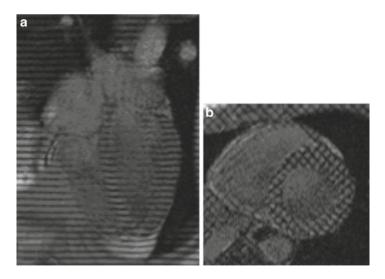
Tagged long-axis (a) and short-axis (b) magnetic resonance images from a normal male human subject
